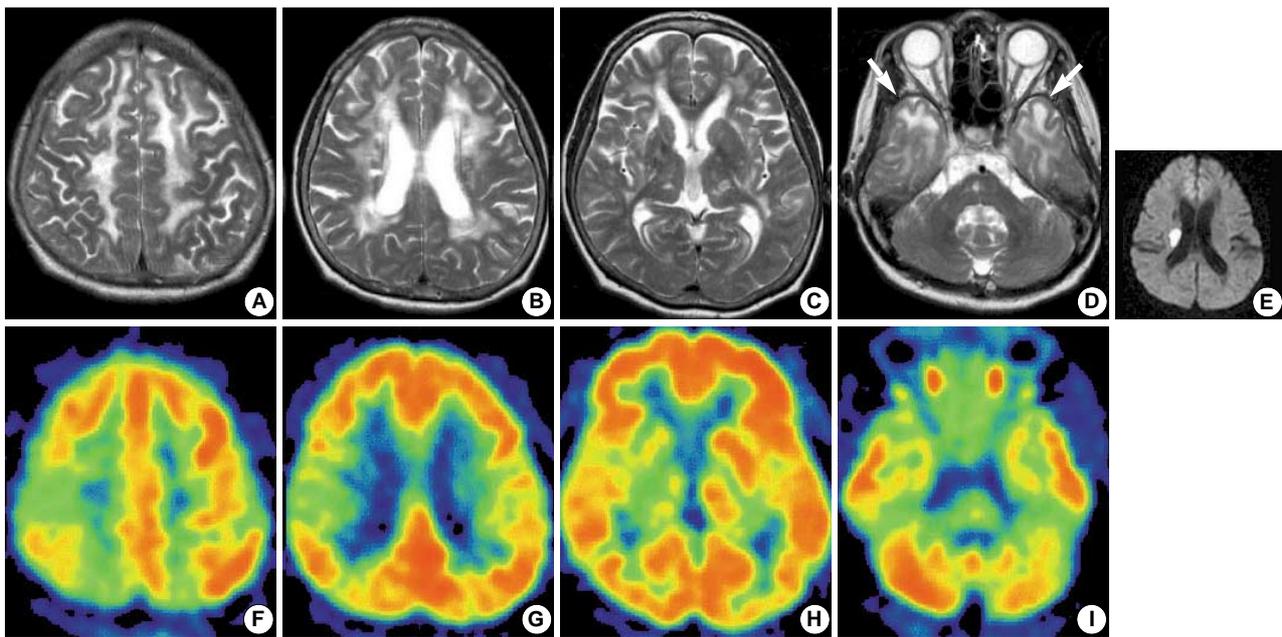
Neuroimaging studies. Axial T2-weighted MR images (A, B, C and D) show 1) diffuse confluent ischemic changes in periventricular and subcortical white matter, 2) lacunes in the basal ganglia, thalamus, and brainstem, and 3) abnormal white matter hyperintensities in both temporal pole areas (arrow). A diffusion-weighted MR images (E) shows high signal intensity, suggestive of recent infarction, in the right corona radiata. FDG-PET scans (F, G, H, and I) obtained with the same angle and slices as in MRI show an abnormally decreased glucose metabolism bilaterally in fronto-parieto-temporal cortices, basal ganglia, and thalamus, more markedly in the right hemisphere than in the left.
